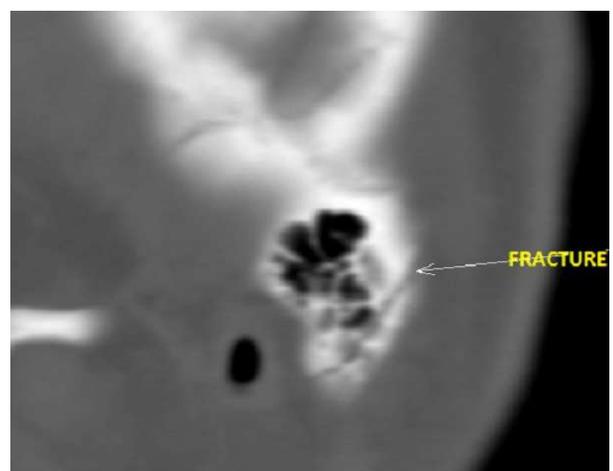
Reconstructed 3D parasagittal view of computed tomogram of temporal bone showing oblique fracture
